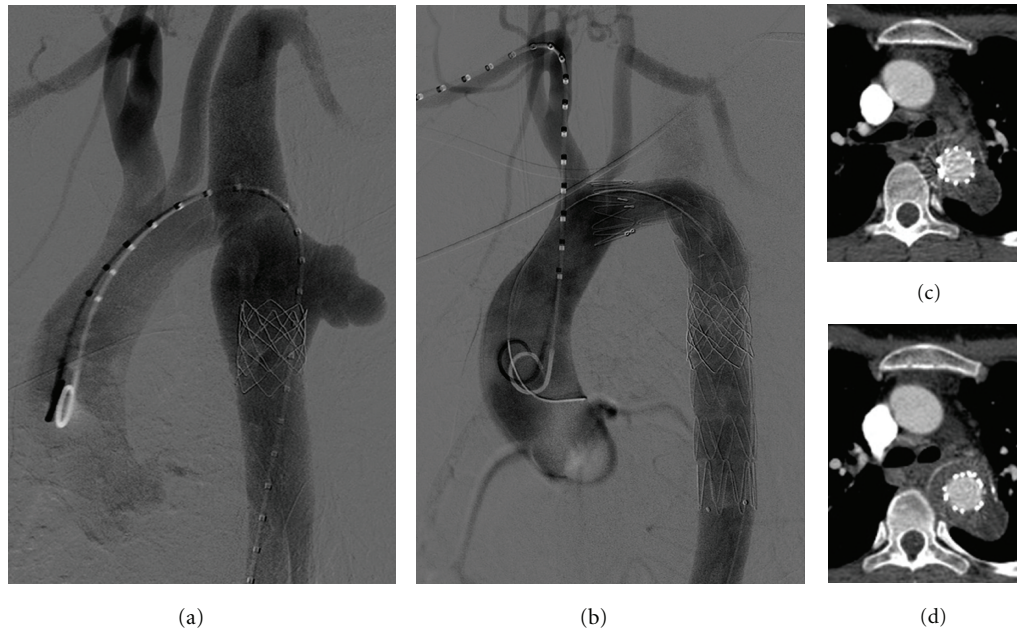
(a) Aortic angiography showing an angulated aortic arch and a small caliber thoracic aorta. A lobulated aortic pseudoaneurysm extends proximally to the left subclavian artery, and a large caliber balloon-expandable stent is adhered to the aortic wall at its distal end. (b) Final result after completion of the carotid subclavian bypass and exclusion of the pseudoaneurysm. A heparin-related leak can be found which extends to the left subclavian artery. (c) and (d) Angio-CT images showing exclusion of the pseudoaneurysm without evidence of leakage.
